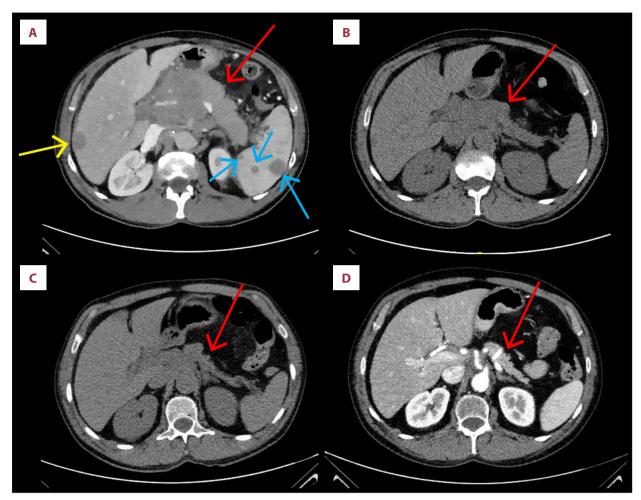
Abdominal Imaging on admission and after treatment. (A) Computed tomography (CT) on presentation: large 9.4×12.2×12.4 cm pancreatic mass (red arrow) with liver (yellow arrow) and splenic lesions (blue arrows). (B) CT after 2 cycles of R-CHOP: significantly decrease size of the pancreatic mass from 12 to 3 cm (red arrow), along with resolution of the ascites and lesions in the liver and spleen. (C) CT after 6 cycles of R-CHOP: smaller 2.2×1 cm pancreatic mass (red arrow) with no lesions in the liver or spleen; Deauville X was assigned. (D) CT: nine months after completion of therapy showed no evidence of a pancreatic mass or metastatic disease.
